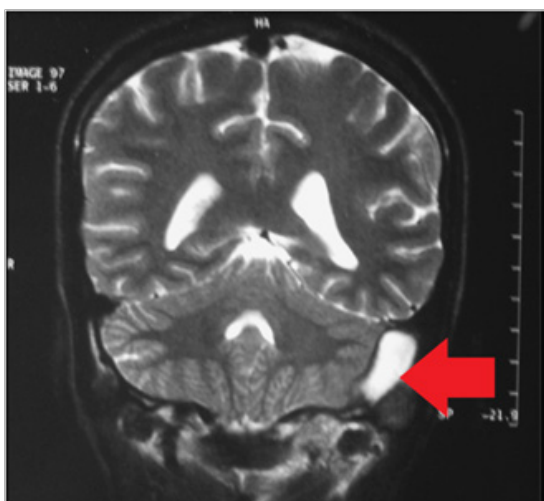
MRI showing (arrow) occlusion and dilatation of left lateral sinus.
